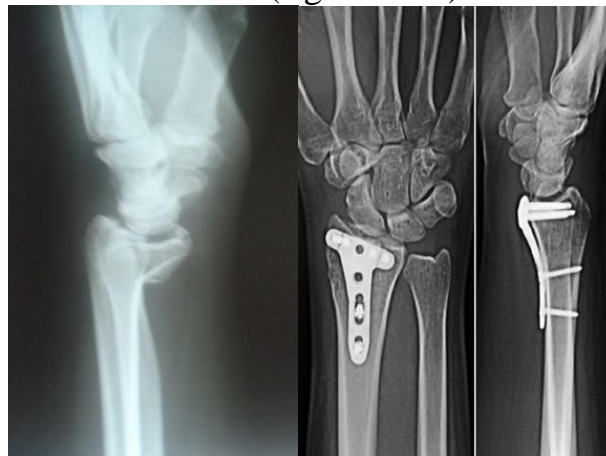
X-Ray and treatment of Barton Fracture.
